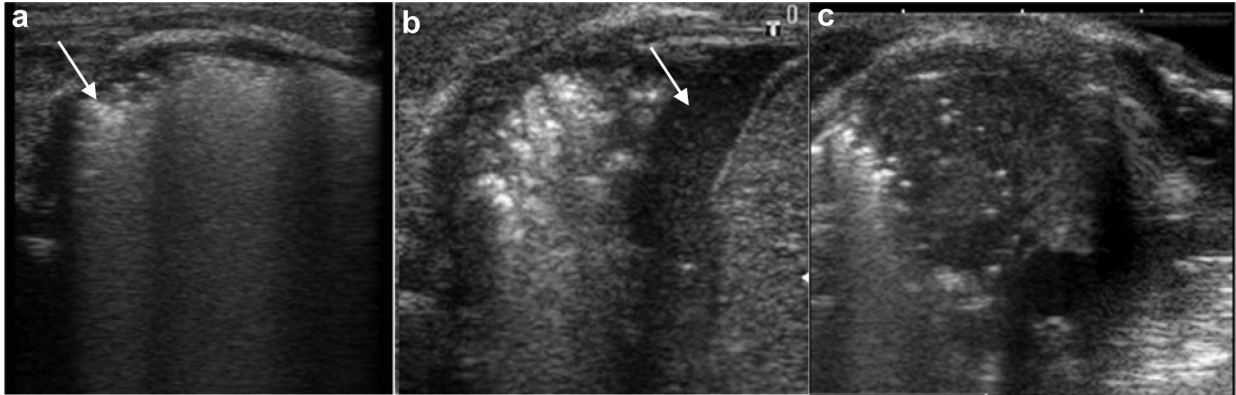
Ultrasound images of pleural line abnormalities, pleural effusion and sub-pleural lung consolidation. (a) Pleural line abnormalities (thick, irregular with small sub-pleural patch of consolidation [arrow]) with a scattered echogenic air bronchogram (arrow). (b) Quad sign: Note the anechoic fluid between the consolidated lung and pleural line (arrow). (c) A large sub-pleural patch of consolidation appears iso-echoic with branching echogenic air bronchogram.
